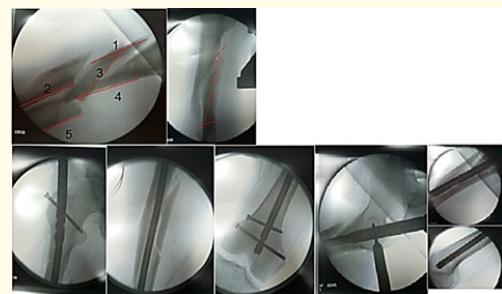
Fluoroscopy and standard X-rays showing multi-fragmentary fracture with a third fragment longer than 5 cm, displaced more than 1 cm, angulation, rotated and managed with closed reduction and intramedullary nailing.
